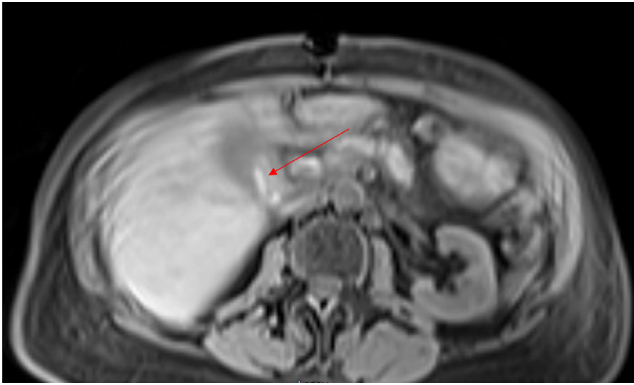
MRCP with the hyperintense signal on T1-weighted imaging within the gallbladder lumen (red arrow), which may reflect the possibility of blood products.
